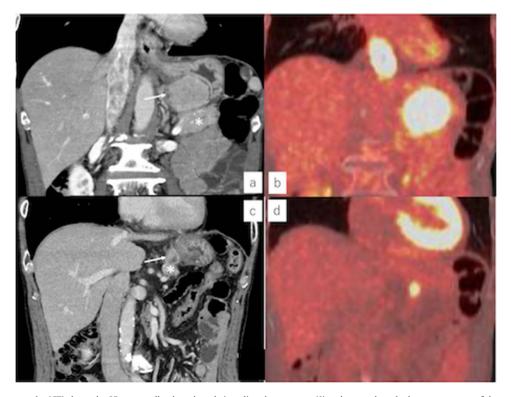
(a) Computed tomography (CT) showed a 65 mm swollen lymph node invading the pancreas (\*) and stomach at the lesser curvature of the stomach (indicated by an arrow). (b) Positron emission tomography (PET)-CT showing fluorodeoxyglucose (FDG) uptake by the lymph node. (c) After DCF and CRT, the invasion to the stomach and pancreas was unclear, (d) but the lymph node displays FDG uptake.
